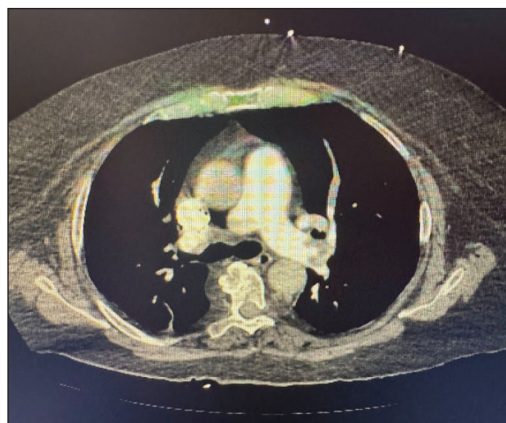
CT revealing high RV/LV ratio of 1.4 and extensive PE with saddle thrombus.
